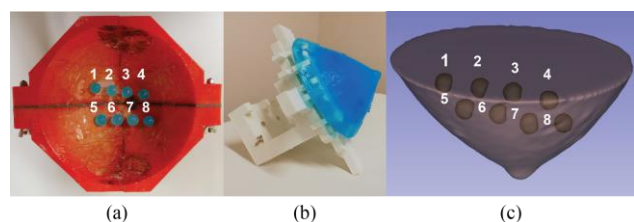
Design of the QBP. (a) The lesions fixed inside the breast mold. (b) The manufactured QBP. (c) A rendered MRI image of the QBP.
